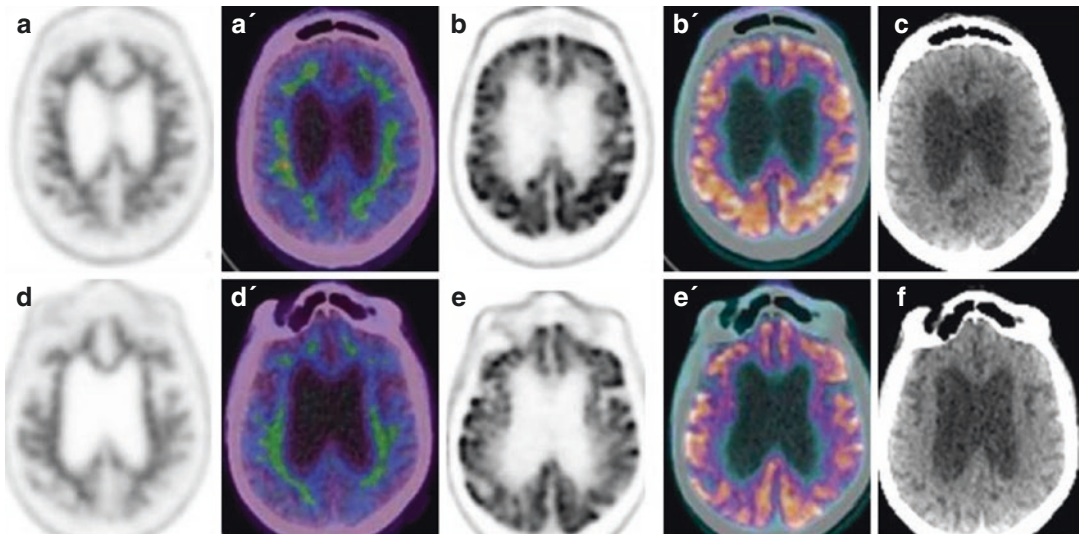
A 59-year-old female patient was examined by ^{18}F -FDG and ^{18}F -flutemetamol PET/CT scans for clinical dementia. Axial ^{18}F -flutemetamol PET (a) and PET/CT (a') views show no significant amyloid burden while axial ^{18}F -FDG PET (b) and PET/CT (b') do not show deficit of glucose metabolism. In corresponding axial CT view is
